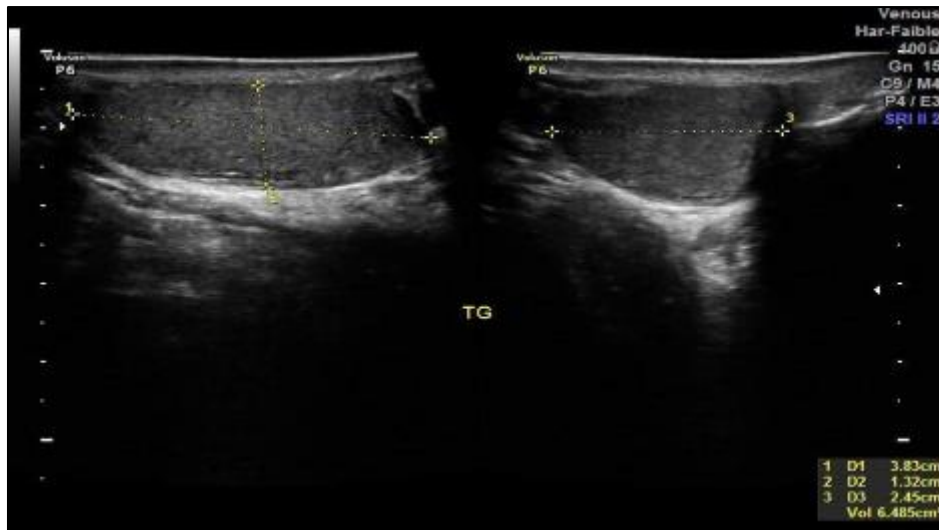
Ultrasound image of the left testicle with a volume of 6.48cm²
